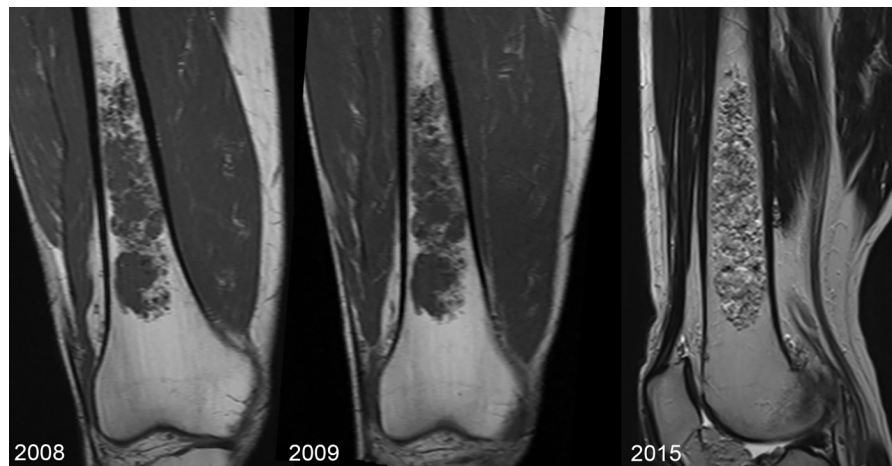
Male, 63 years: Enchondroma. MRI for evaluation of meniscal problems. The length (126 mm) and structural characteristics of “rings and arcs” remained unchanged over 7 years. In 2015 only sagittal images were provided. Clinically the patient is asymptomatic in 2021.
